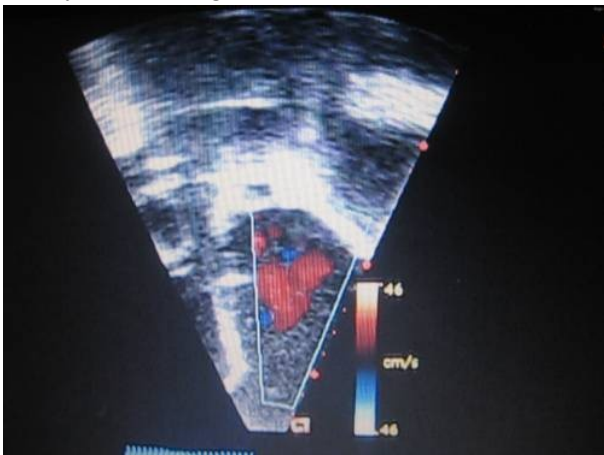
Color Doppler showing that the cavity had a direct communication with the normal sized left atrium.
